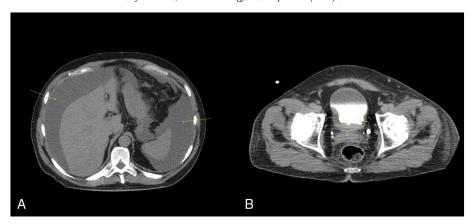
CT scan images of angiosarcoma. (A) Noncontrast axial CT scan through the upper abdomen demonstrates low density ascites filling the peritoneal cavity. (B) CT scan of urinary bladder tumor. An axial image from an IV contrast enhanced CT urogram shows an irregular mass causing thickening of the right lateral, posterior, and left posterolateral bladder wall.
